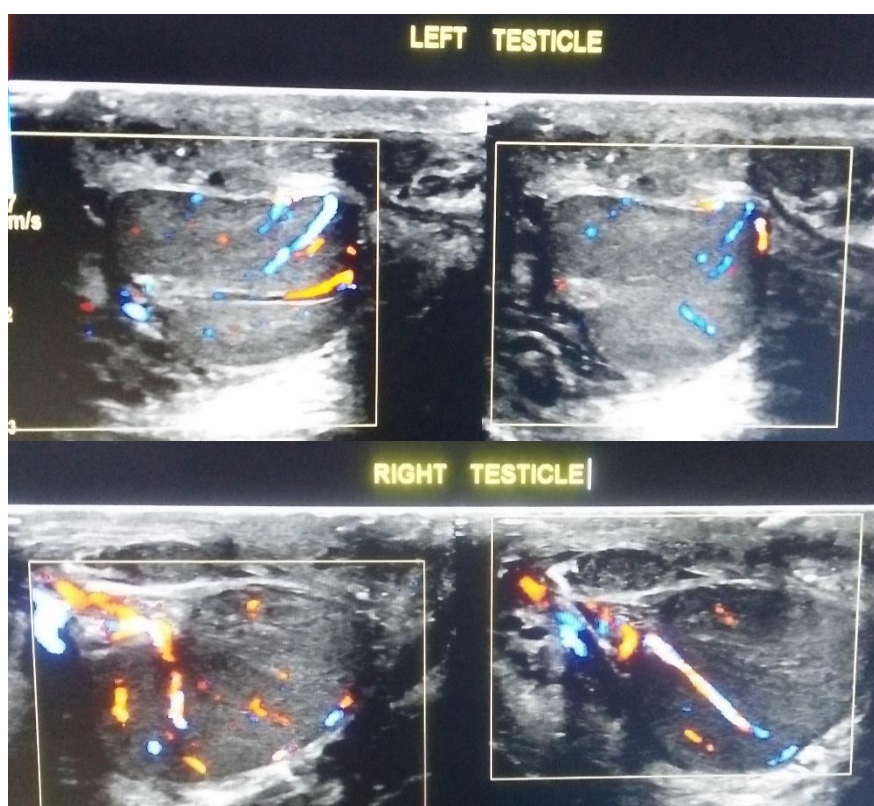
Postoperative Doppler scrotal ultrasonography showing intact vascularity of left testicle (Upper picture) and right testicle (Lower picture).
